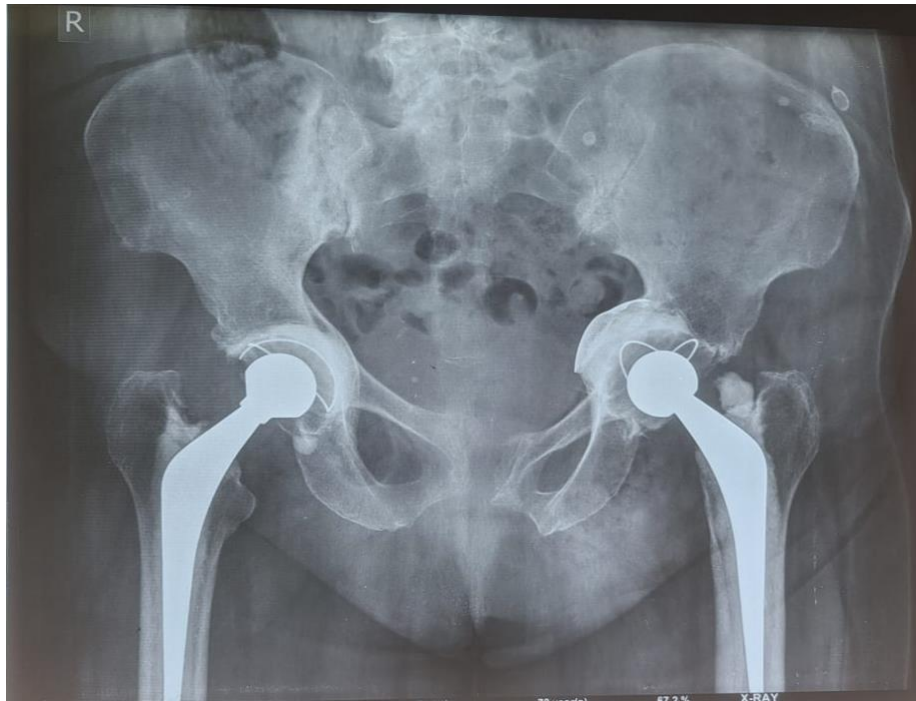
Post-operative radiograph at 7 year follow up of Bilateral THR.
